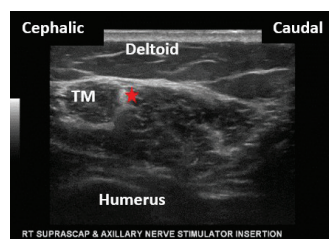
US image parallel to the humeral shaft showing an out-of-plane approach to the axillary nerve. The red star indicates needle placement. US: ultrasound; TM: teres minor.
